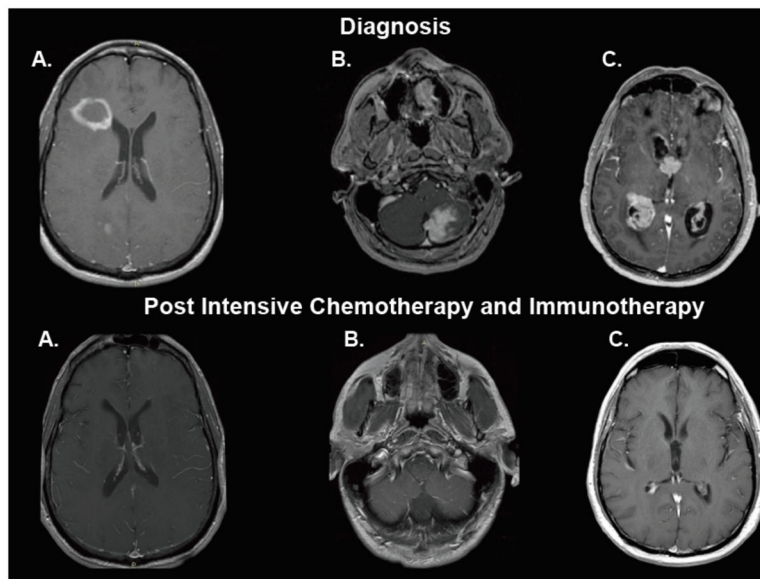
Distinct radiographic presentations of central nervous system lymphomas and durable responses to intensive chemotherapy and immunotherapy, Without whole brain radiotherapy (T1 axial, post-gadolinium magnetic resonance imaging, at diagnosis and at restaging, at least two months after completion of therapy)
